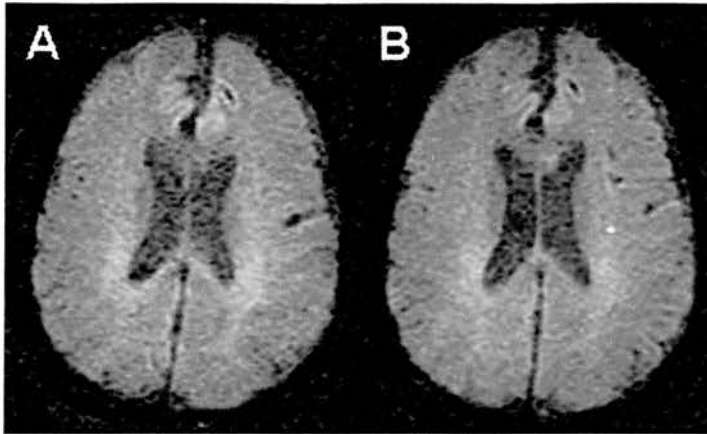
A. Normal scan at baseline (no DWI lesion seen, no vessel occlusion and no perfusion abnormality) in a 79 year old male patient with a left hemispheric TIA lasting 90 minutes – B. The patient remained clinically asymptomatic. B shows a small new DWI lesion in left MCA territory seen at 30days on follow up MR.
